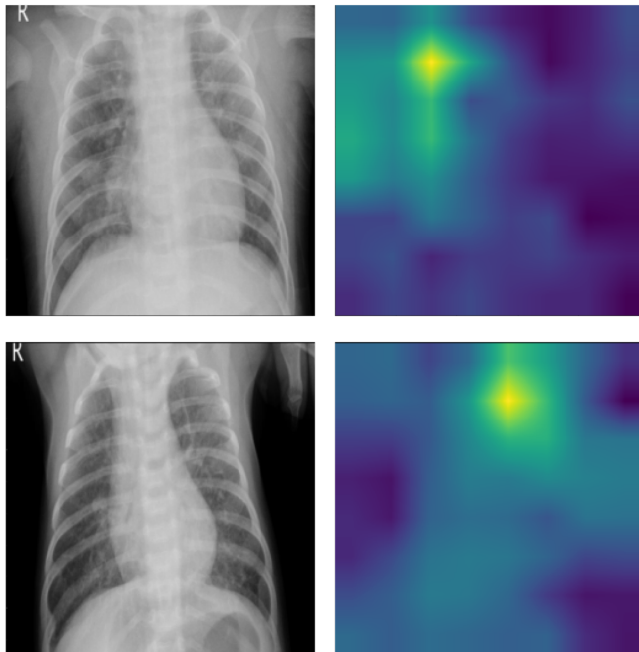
Two CAM visualizations for pediatric chest X-ray pneumonia classification on the Mendeley-V2 dataset with chest X-ray on the left and CAM on the right. The CAMs reveal that the model correctly focuses on the corresponding areas that show some concerns about pneumonia.
